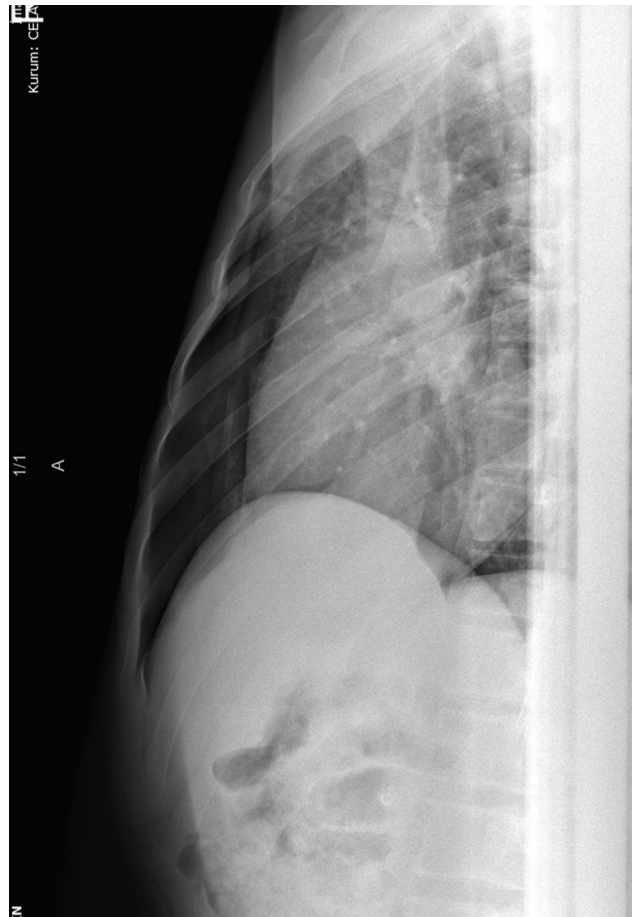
Occult pneumothorax detected by OCXR. OCXR: oblique chest X-ray
